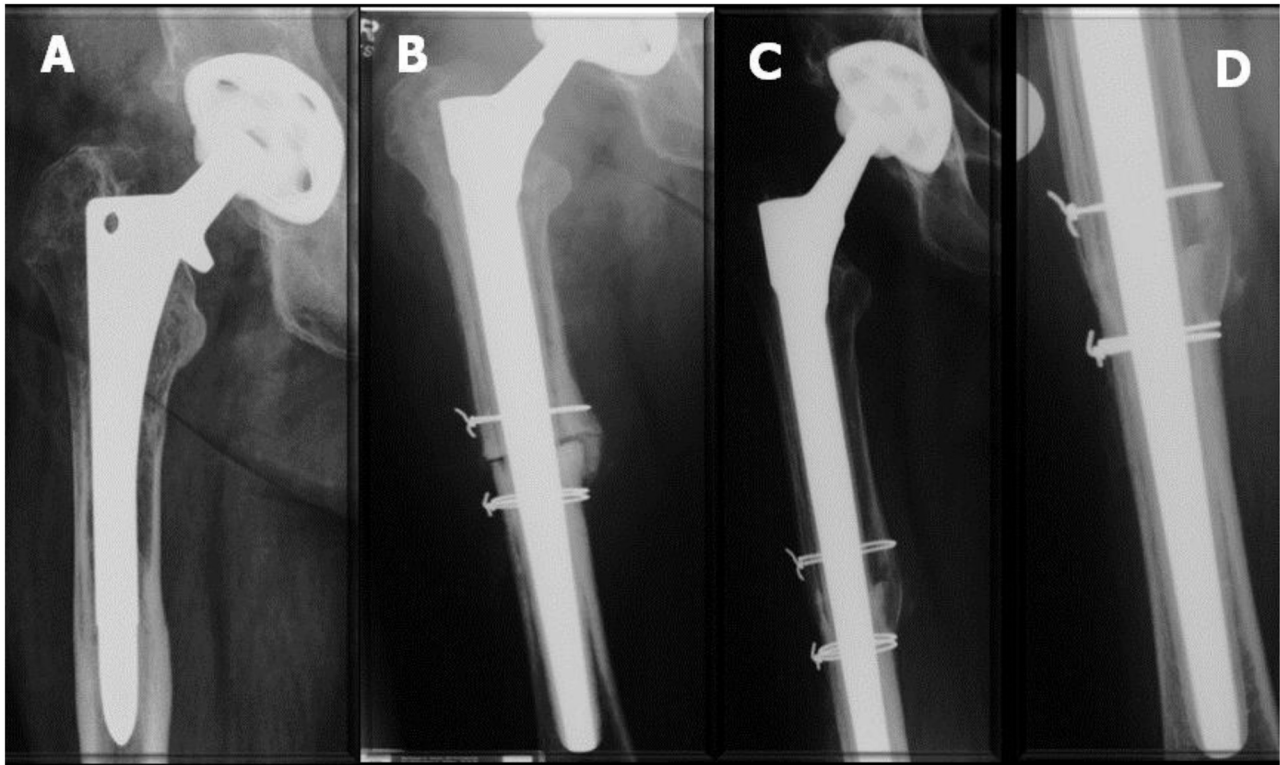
(A) Pre-operative radiograph showing severe stress shielding and paper-thin cortex (B) One year post revision surgery with Wagner SL stem (C, D) Five years post-operative radiograph showing a well-fixed and osseointegrated implant and good consolidation of the osteotomy.
